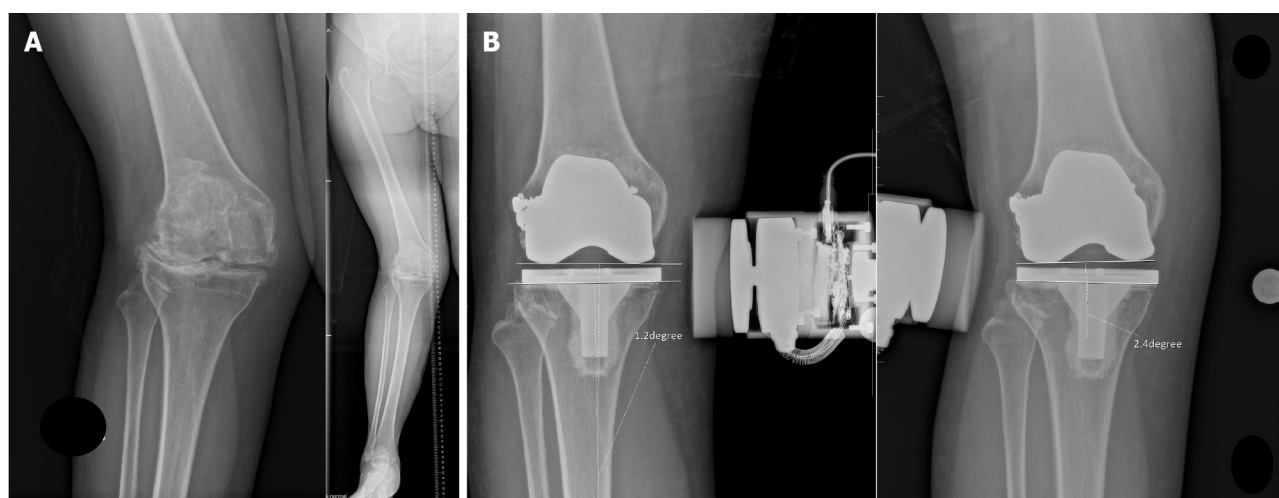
A case of a 65-year-old female with severe valgus osteoarthritis of the knee. A: The preoperative radiograph shows a valgus deviation of the mechanical axis of 22 degrees. After initial soft tissue release, persistent tightness of the lateral structure was still noted, causing an unbalanced extension gap. Thus, a lateral condylar sliding osteotomy was performed intraoperatively; B: The knee was stable after stress radiography.
